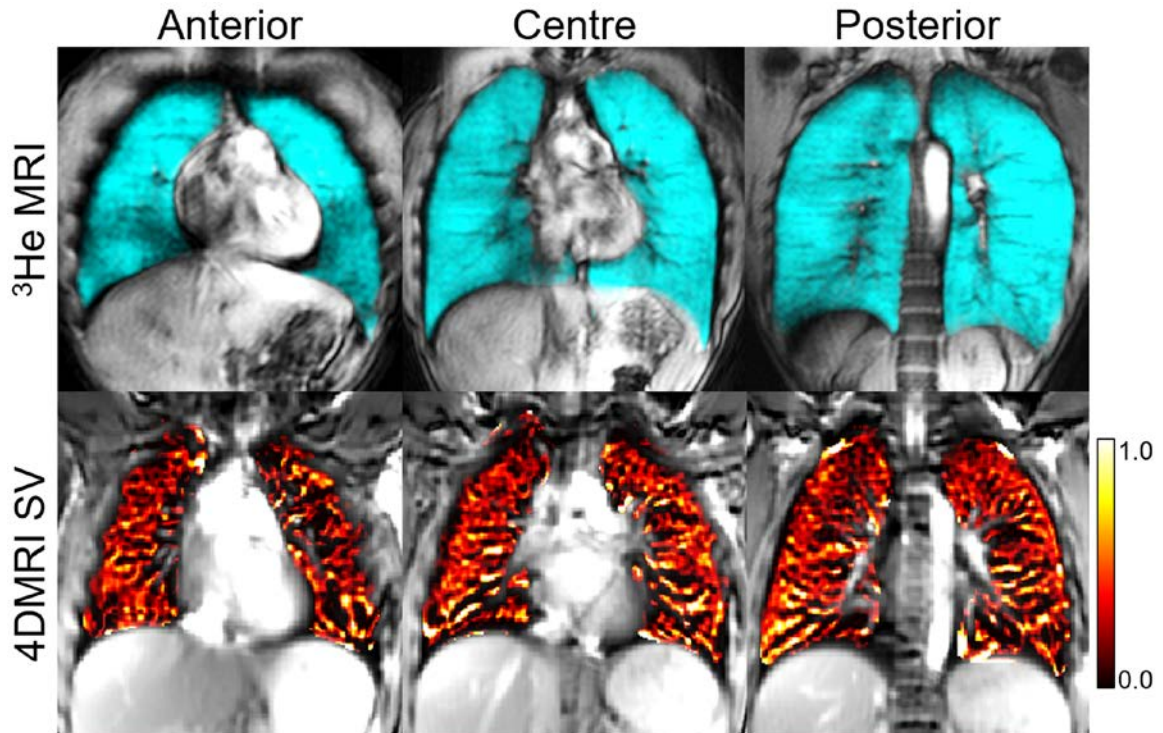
³He MRI and 4DMRI for a Representative Healthy Subject
